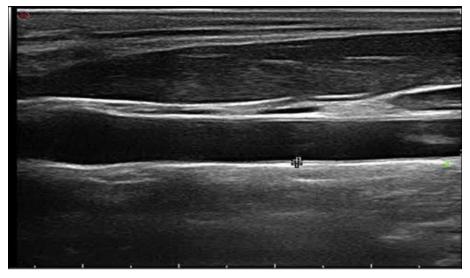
Carotid ultrasonography of a control case showing normal IMT (IMT =0.60 mm).
